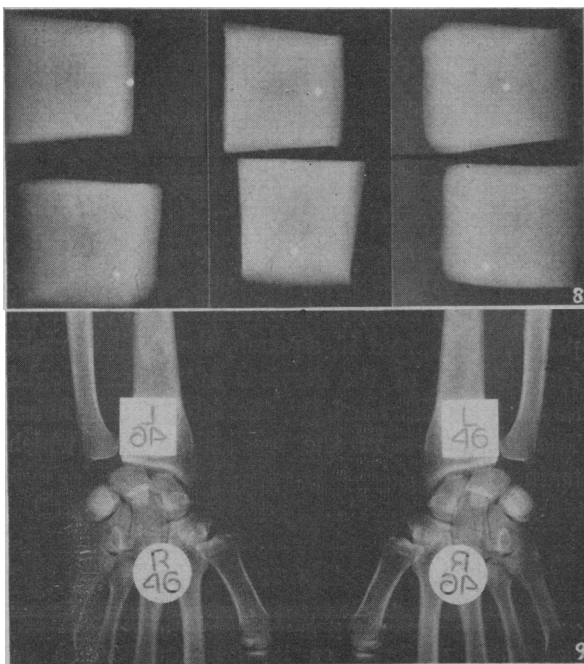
Shows a series of radiographs of a paraffin block with a small piece of metal embedded in one edge. One view, the upper left, shows the metal in its proper relationship to the block. Each of the other five shows a false relationship. It is quite easy to realize that a foreign body may appear to be situated anywhere in the tissues except in its real location and especially to imagine that a foreign body lies in a bone when really it is only at the surface. Our analysis of our immediate visual impressions is based on our past experience of visual impressions and their relationship to reality.
